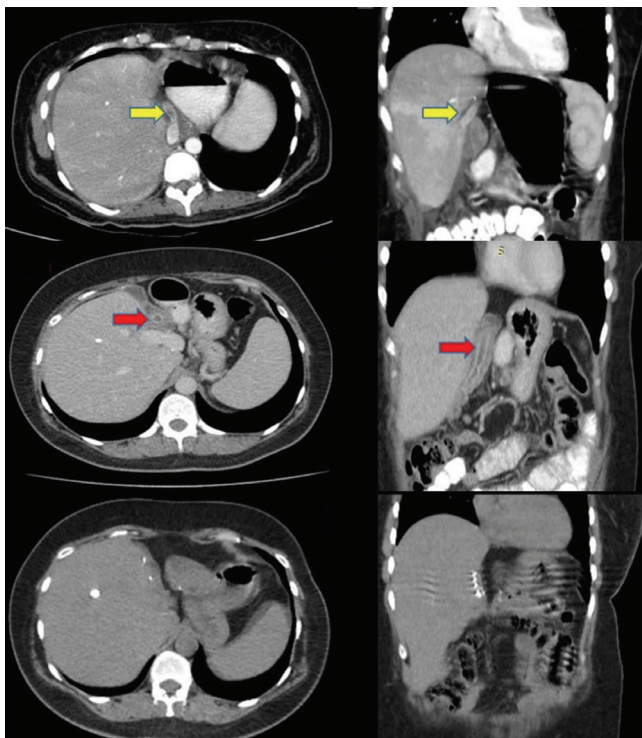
Thrombosis in vascular graft on the 3rd postoperative month. Computed tomography, coronal and axial views (yellow arrows). Vascular graft transmigration into duodenum (red arrows). Vascular graft was not seen in the new computed tomography.
